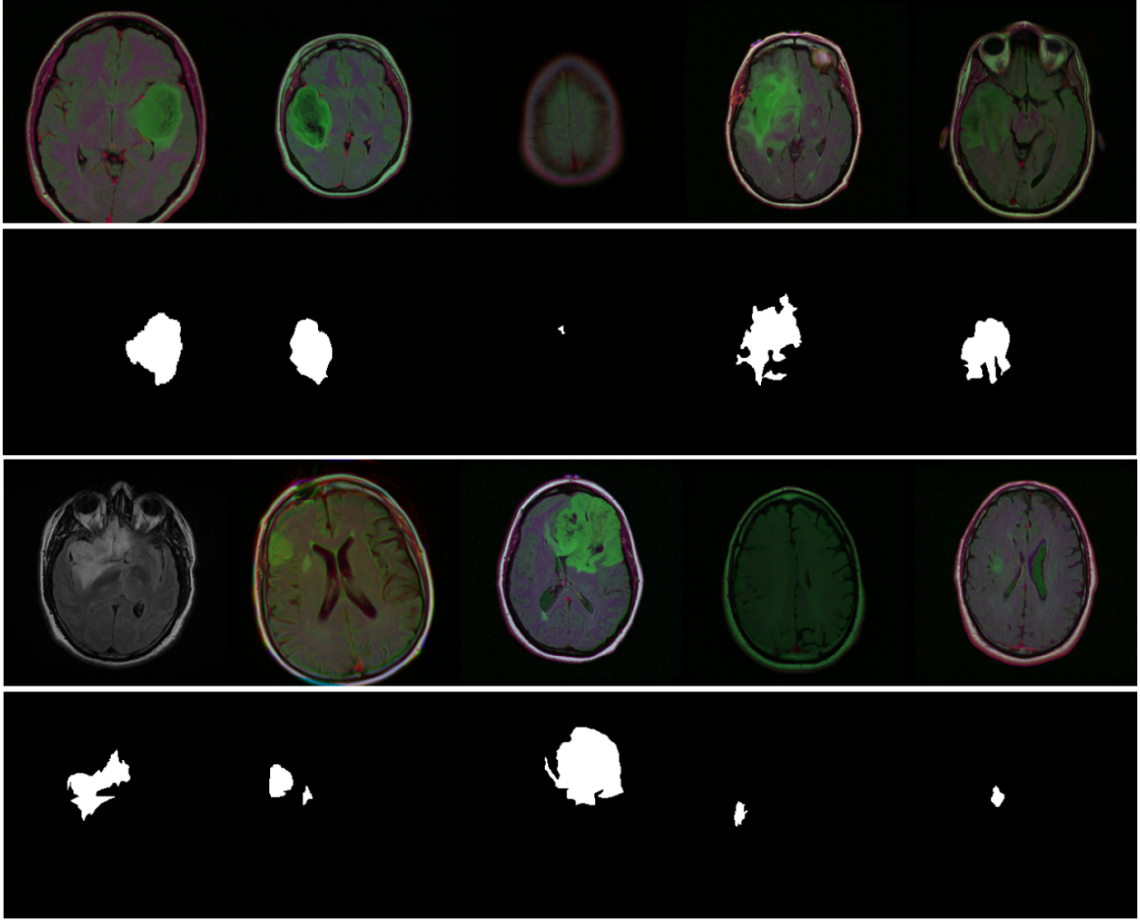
MRI images from the dataset with corresponding tumor masks. MRI images(1st and 3rd rows) and corresponding Tumor masks(2nd and 4th rows)
